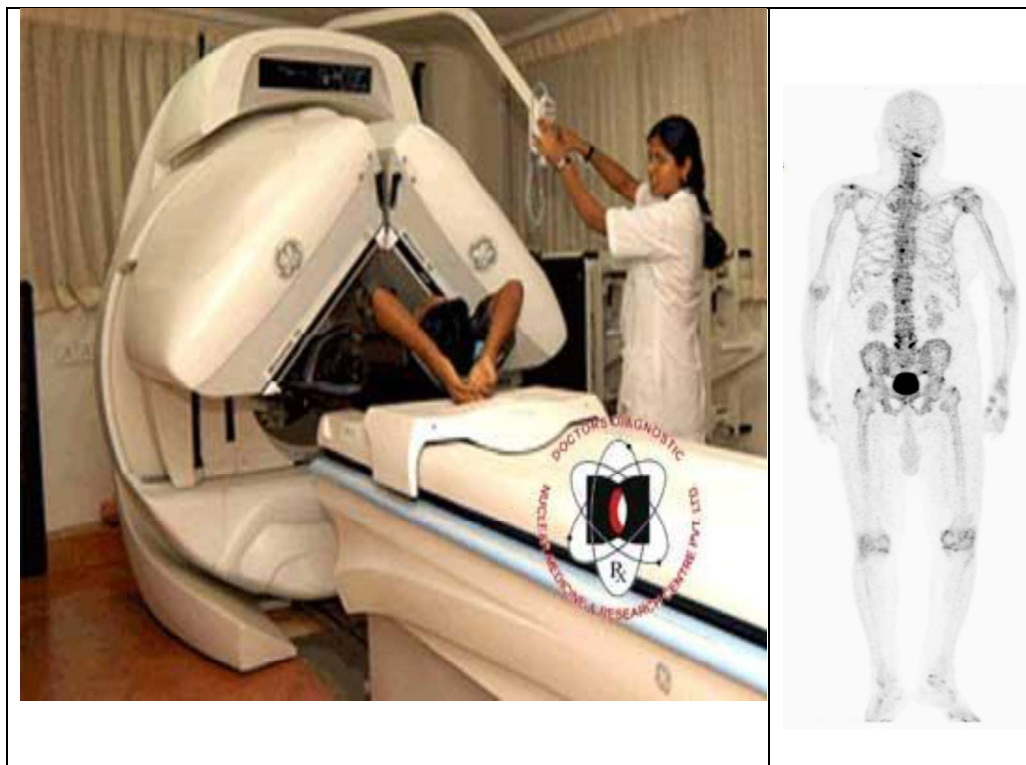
A patient undergoing SPECT imaging. The planar image on the right is of a patient injected with ^{99m}Tc -MDP (methylene diphosphonate). Abnormal uptakes seen in certain parts of the bone correspond to bone metastasis.
